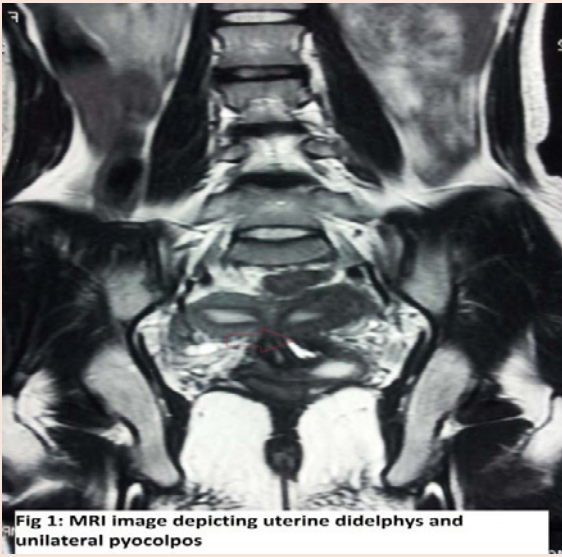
MRI image depicting uterine didelphys and unilateral pyocolpos
